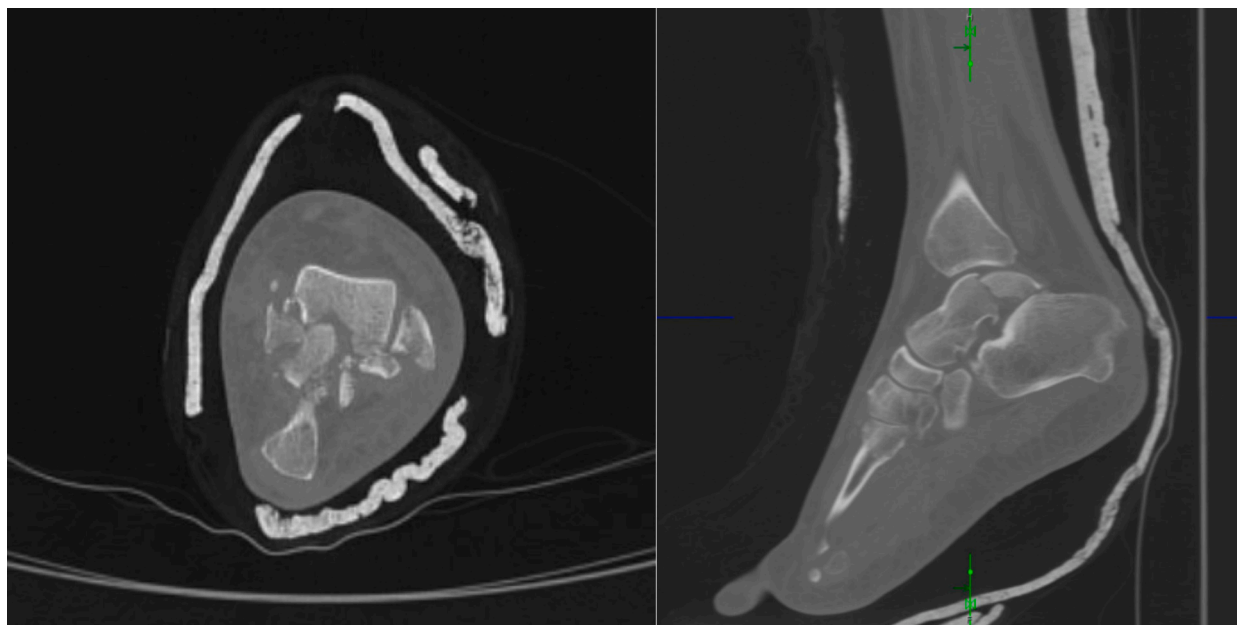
Preoperative axial (left) and sagittal (right) computed tomography without contrast noting a coronally oriented displaced fracture of the talar dome/body.
